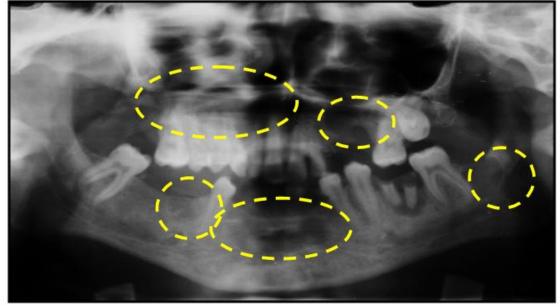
A screening orthopantomograph revealing multiple unilocular radiolucencies in the maxilla and mandible (circles).
